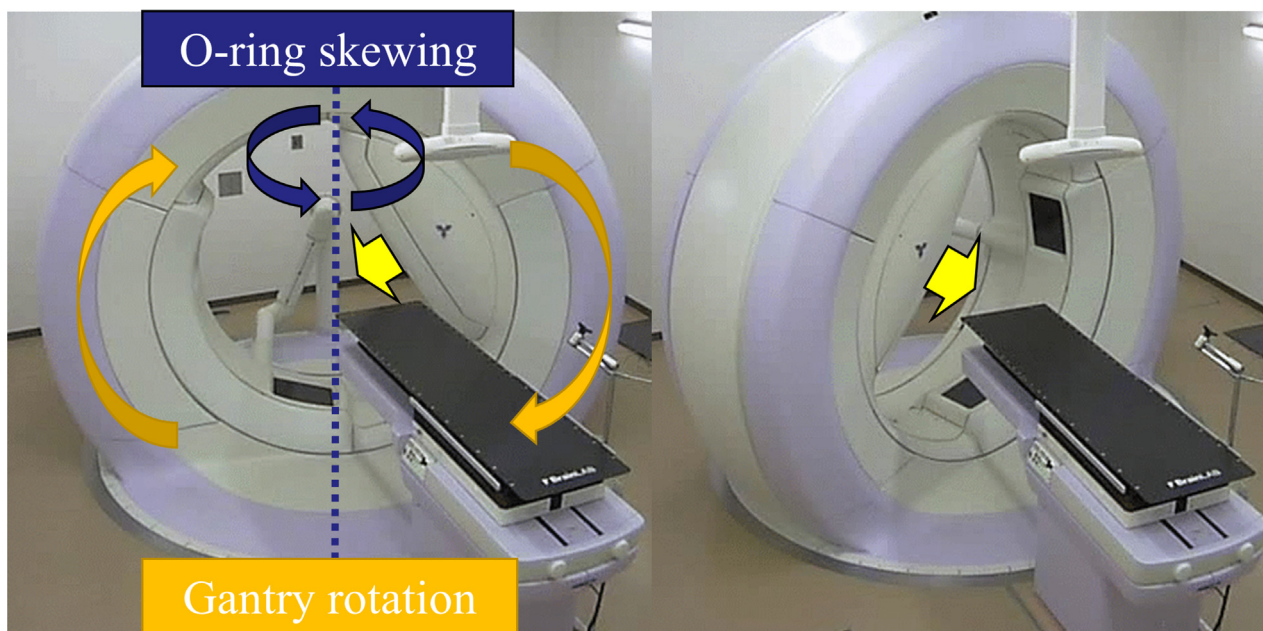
The Vero4DRT has an X-ray head (arrow) that can rotate around the inner surface of the O-ring. The O-ring gantry can also skew around the vertical axis, enabling delivery of DWA therapy.
